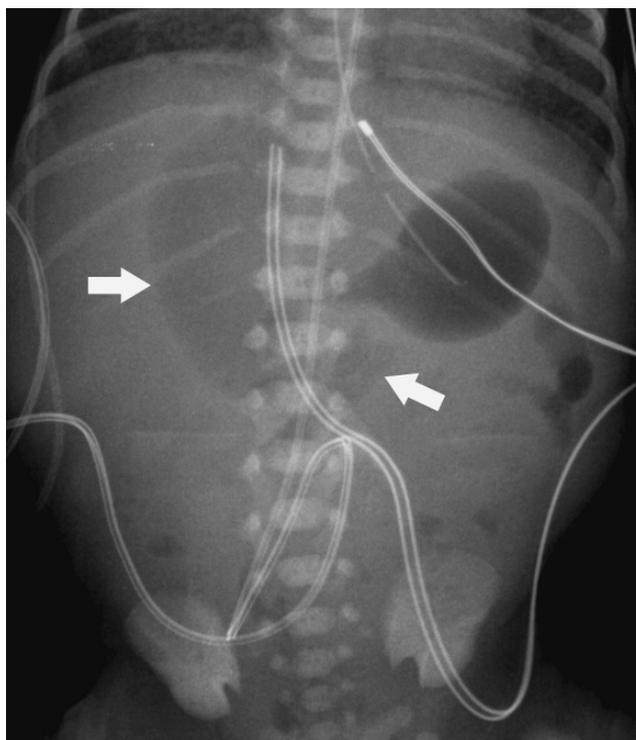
Pneumoperitoneum. Free air on supine radiograph (arrows) seen as abnormal lucency in the right upper quadrant.
